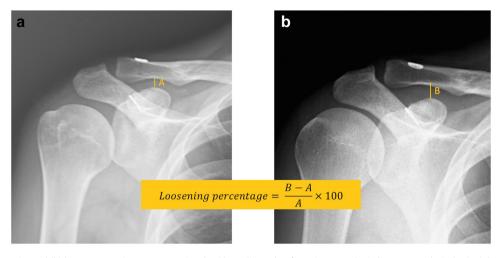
(a) Early postoperative and (b) late postoperative anteroposterior shoulder radiographs of a patient. A and B indicate coracoclavicular (CC) distances measured on these radiographs. Loosening ratio = (B-A)/A*100
